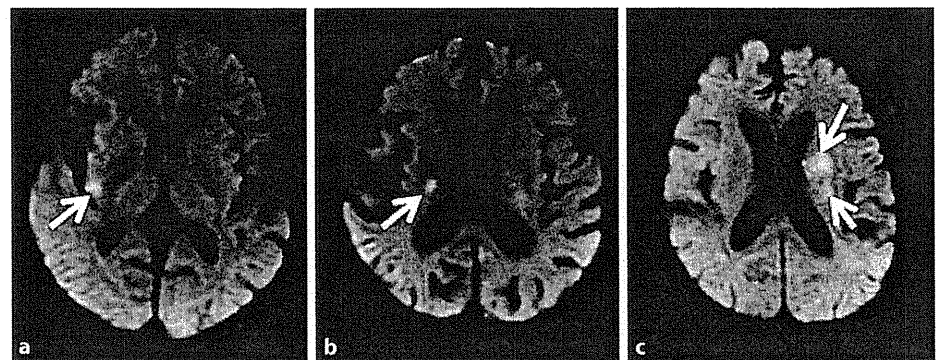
Initial DWI before t-PA infusion: a cortical lesion, b subcortical lesion of diameter <15 mm, and c subcortical lesion of diameter ≥15 mm.
